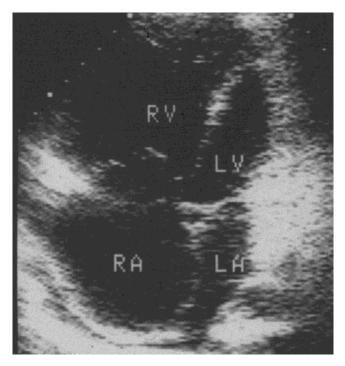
Four-chamber view from two-dimensional echocardiogram reveals marked right ventricular hypertrophy and right atrial enlargement.
